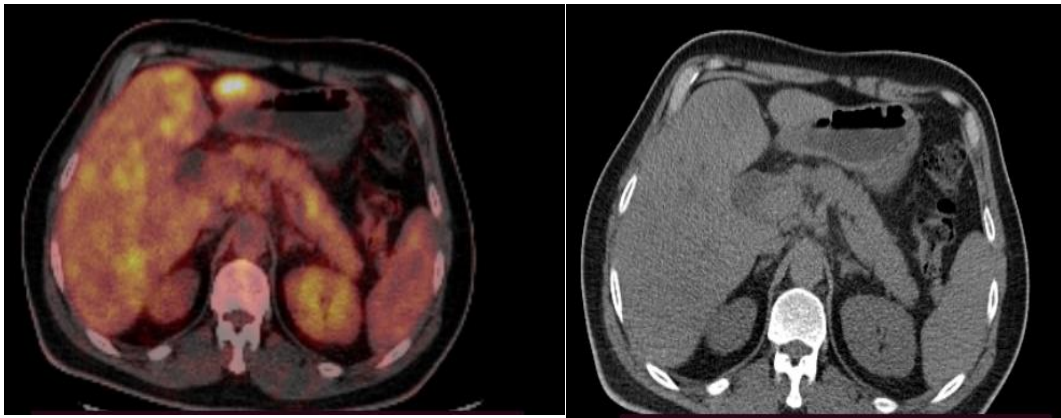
57-year-old patient diagnosed with pancreatic adenocarcinoma. PET/CT showed hepatic focal lesion which is not seen in CT which resulted in upstaging of the patient from M0 to M1 saving the patient from unnecessary surgery.
